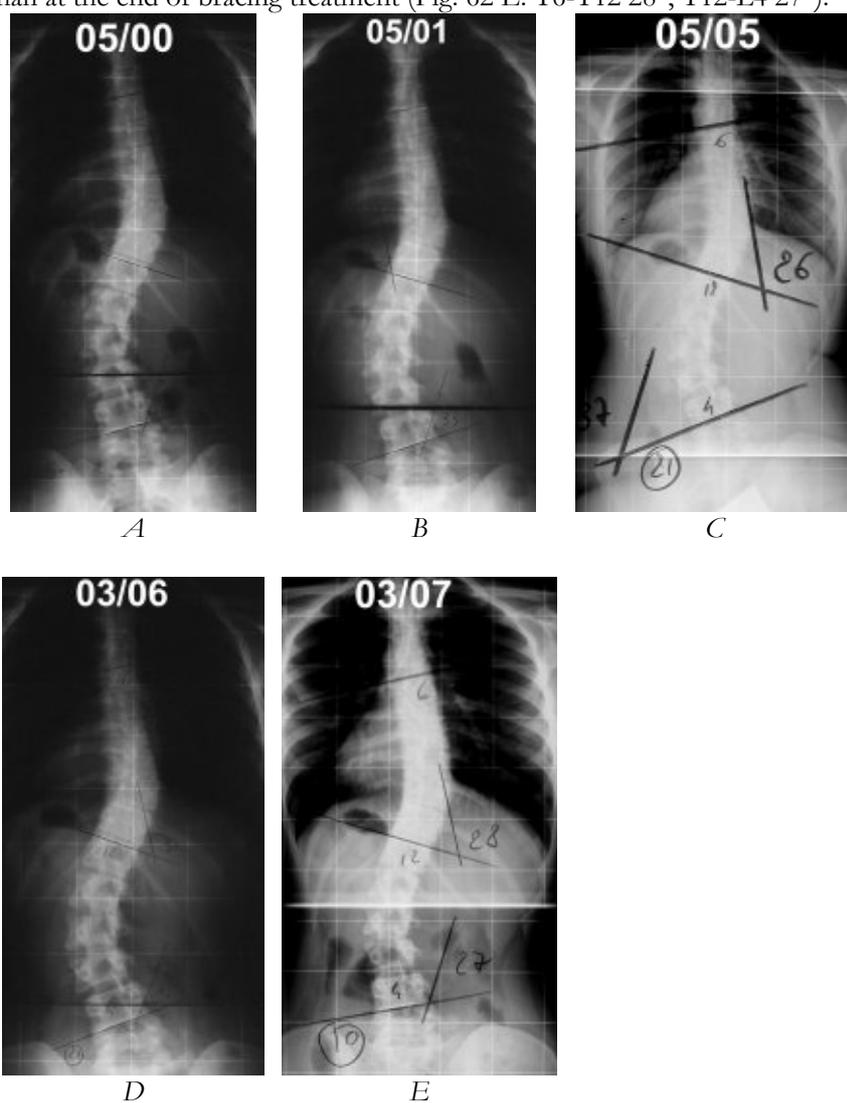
Case history of Anna. In each radiograph month and year are represented, while Cobb degrees have been reported in the text.
